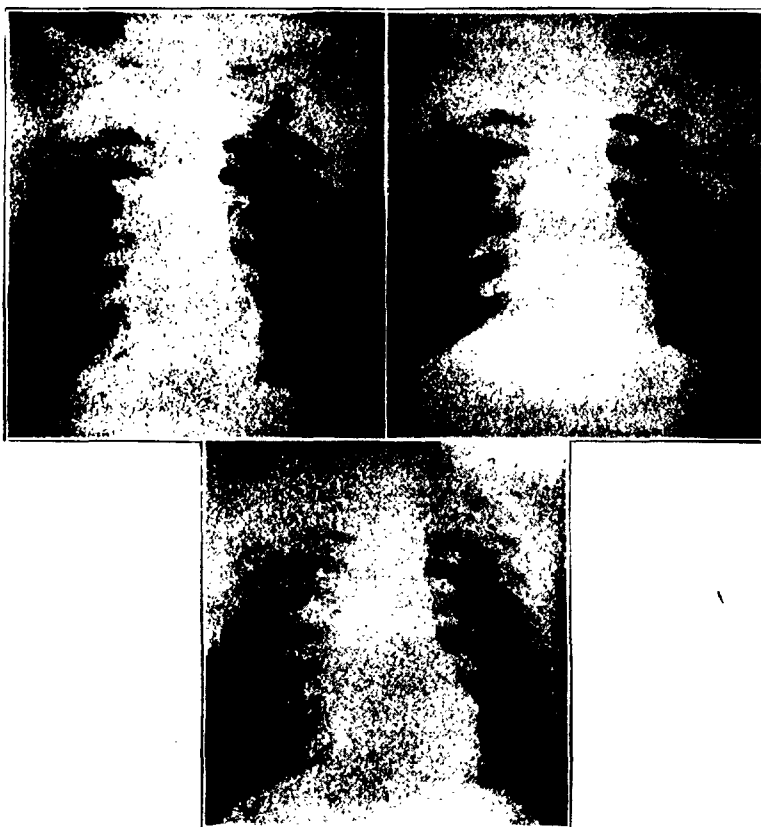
(case 4).—Serial roentgenograms taken in 1936 (A), 1943 (B) and 1946 (C) showing infection in the upper lobe of the right lung which has developed in the presence of definite nodulation. There is also suggestive evidence of infection in roentgenogram B (1943) in the upper lobe of the left lung. There has been no appreciable change in the 1946 roentgenogram over the 1943 roentgenogram.
